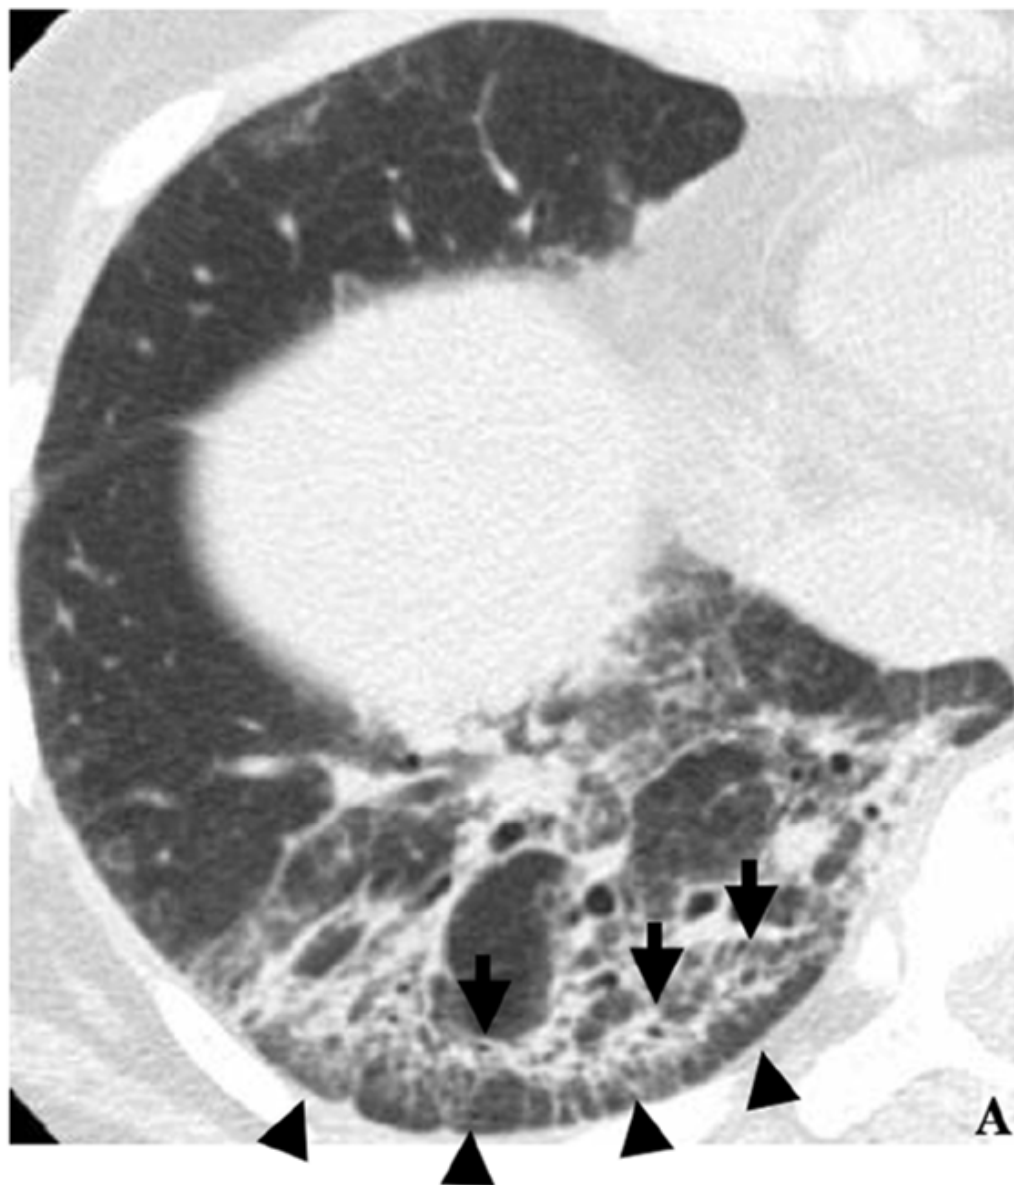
HRCT images showing lower reticulation pattern. A: A 47-year-old woman
